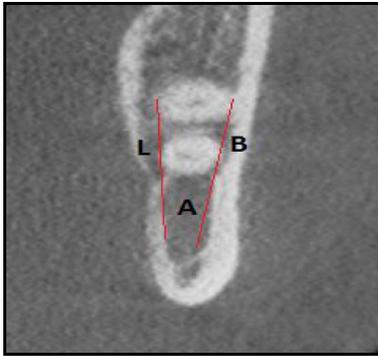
Bucco-lingual position of mandibular canal regarding third molar roots on CBCT. Classes: A: Apical, B: Buccal, L: Lingual.
